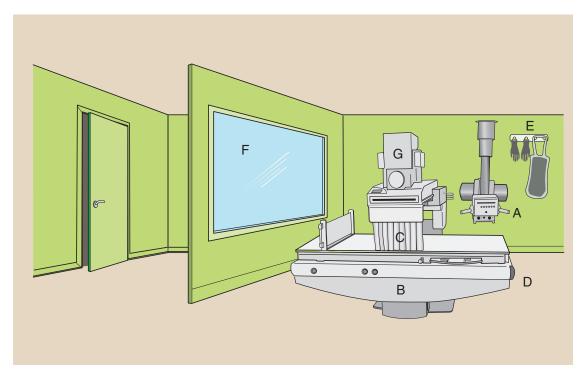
The general purpose radiographic and fluoroscopic imaging system includes an overhead radiographic tube (A) and a fluoroscopic examining table (B) with an x-ray tube under the table. Some of the more common radiation protection devices are the lead curtain (C), the Bucky slot cover (D), a leaded apron and gloves (E), and the protective viewing window (F). The location of the image intensifier (G) and of associated imaging equipment is shown.
